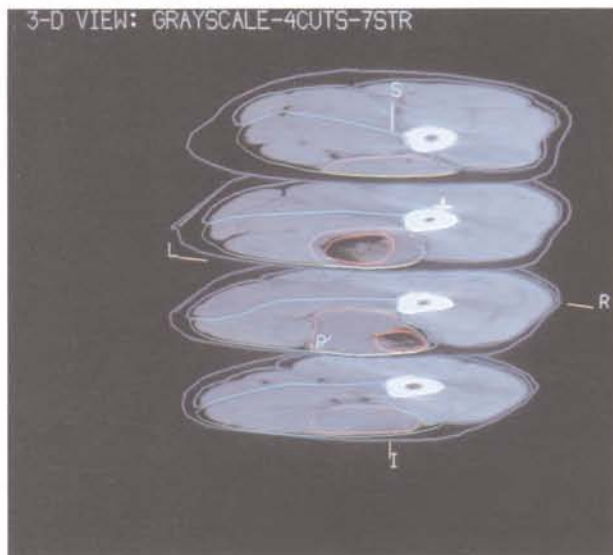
c. Multiple-plane display of 4 of the 8 CT sections taken before surgery. In each section, the external contour and outlines of bone, muscle compartments, and gross tumor are visualised.
